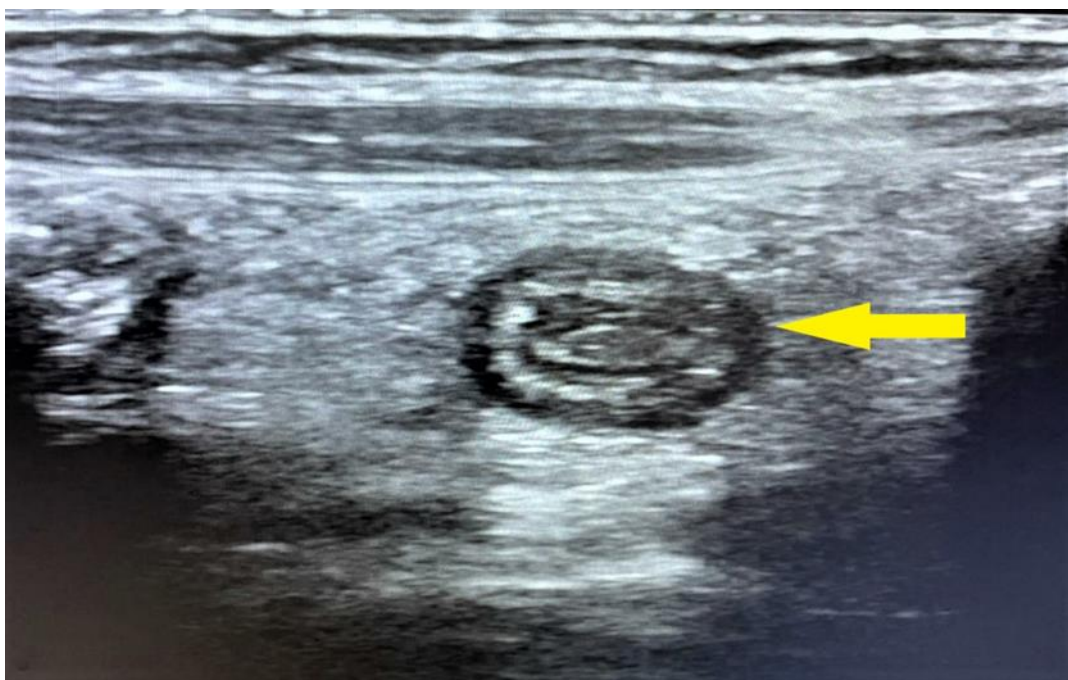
Ultrasonographic image in the pre-operative period showing “Target Sign”.
